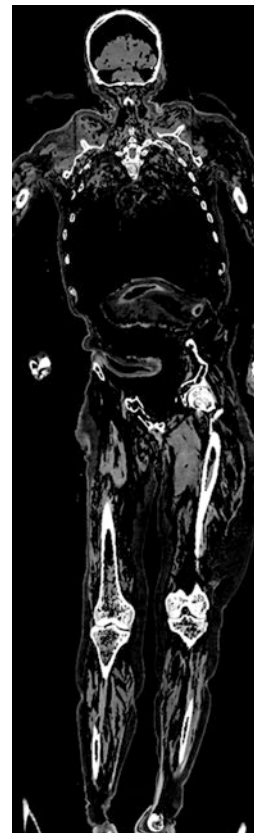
Coronal noncontrast computed tomography (CT) scan showing multiple rib and pelvic fractures advanced post-mortal changes
